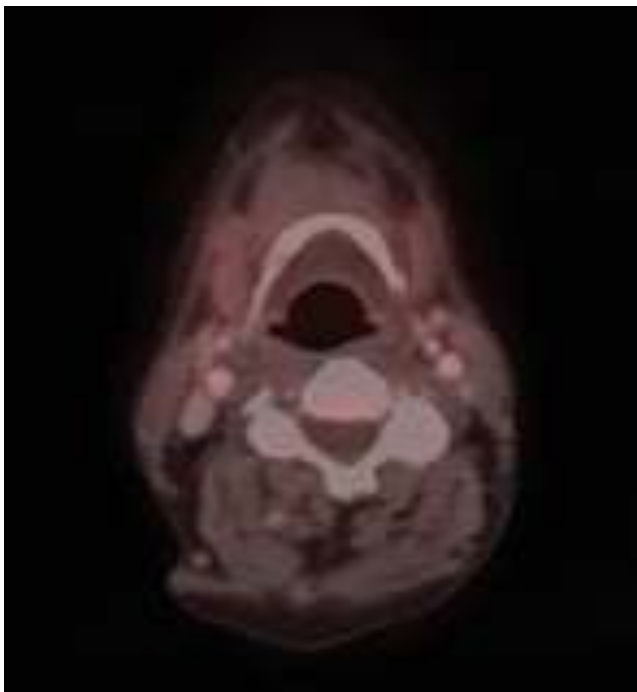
Transaxial fusion PET-CT image of neck shows no abnormal FDG uptake in pyriform sinus.
